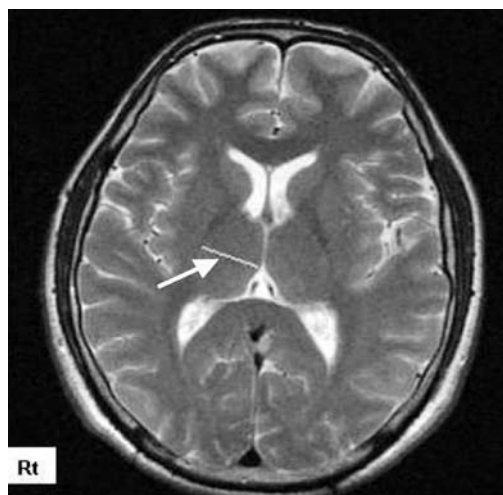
Measurement of the transverse length (arrow) of right thalamus in magnetic resonance imaging.
